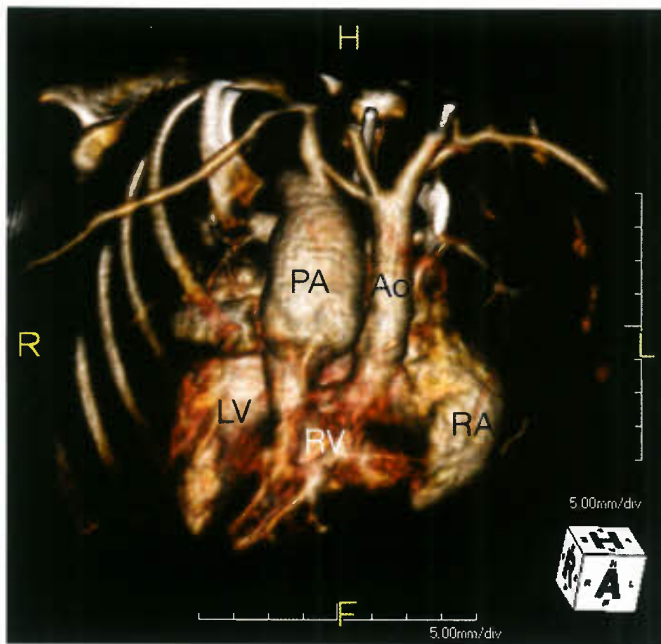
For patients with complex aortic arch anatomy, angiography may further define associated aortic arch coarctation, hypoplasia, or interruption. CT angiogram: Hypoplastic ascending aorta nearly side by side and leftward of the pulmonary artery with associated aortic arch hypoplasia. PA, Pulmonary artery; Ao, Aorta; LV, Left ventricle; RV, Right ventricle; RA, right atrium; H, Head; R, Right; F, Front; L, Left
